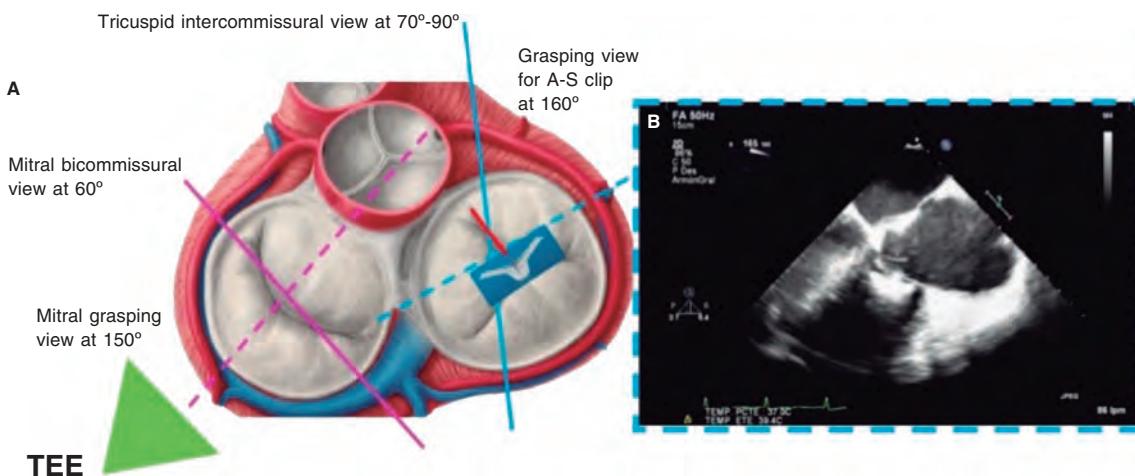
Search for the grasping view for the clip in the anteroseptal (A-S) position with respect to the center of the tricuspid valve. A: grasping view for A-S clip (discontinuous blue line). B: transesophageal echocardiogram (TEE) at 160° showing the clip with wide open arms and the anterior and septal leaflets resting on them.
